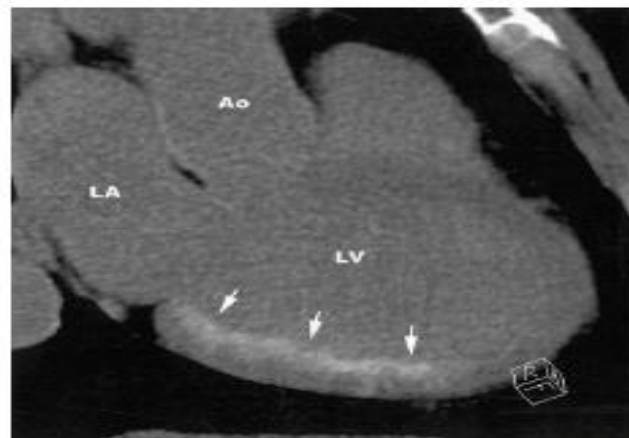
64-Slice CT Scan 51 Min After a Primary Angioplasty for an AMI of a 59-Year-Old Patient
